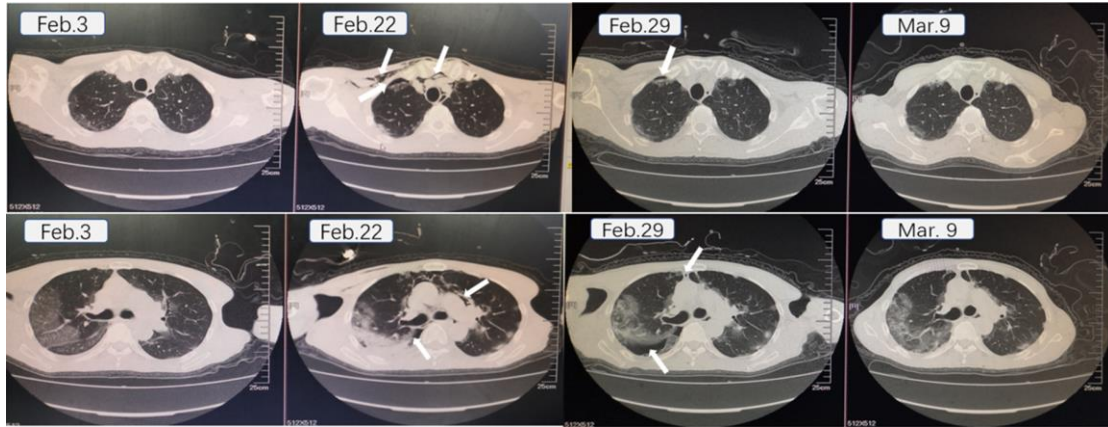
Chest computed tomography (CT) image shows multiple ground glass opacities and infiltrations in both lungs on Feb 3. Chest CT on 22 February 2020 revealed multiple ground-glass opacities with parenchymal consolidation, pneumothorax on the right, pneumomediastinum and subcutaneous emphysema. Pneumothorax, ,pneumomediastinum and subcutaneous emphysema was absorbed by 9 March.
